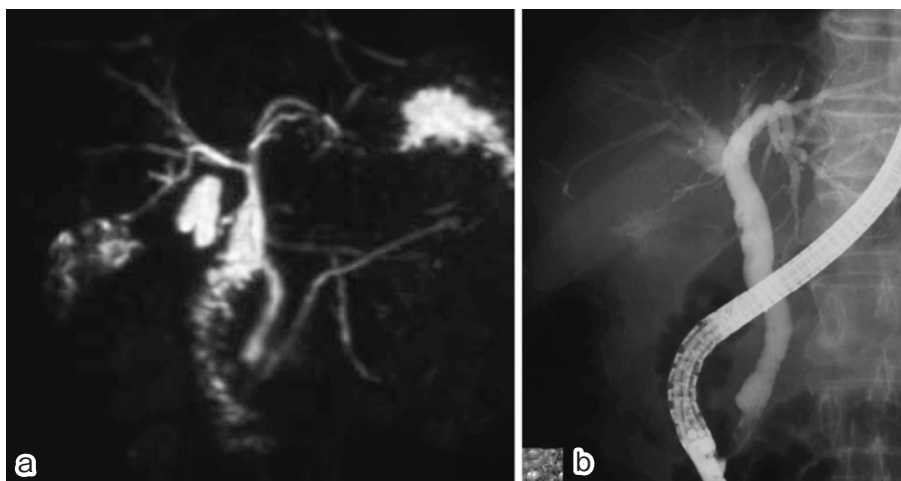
Magnetic resonance cholangiopancreatography showed a lesion of moderate-to-high signal intensity on T2-weighted images in segment 5 (a). Endoscopic retrograde cholangiopancreatography demonstrated a common bile duct stone. The intrahepatic bile ducts of segment 5 were not evident after injection of contrast material (b).
